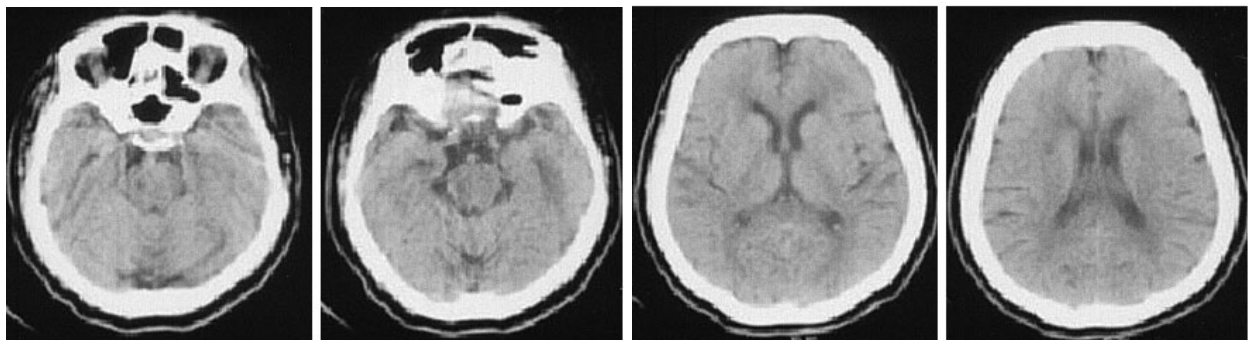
Brain CT showed a low density over the right corona radiata and old multiple infarcts in the right basal ganglia, the right corona radiata, and the pons.
